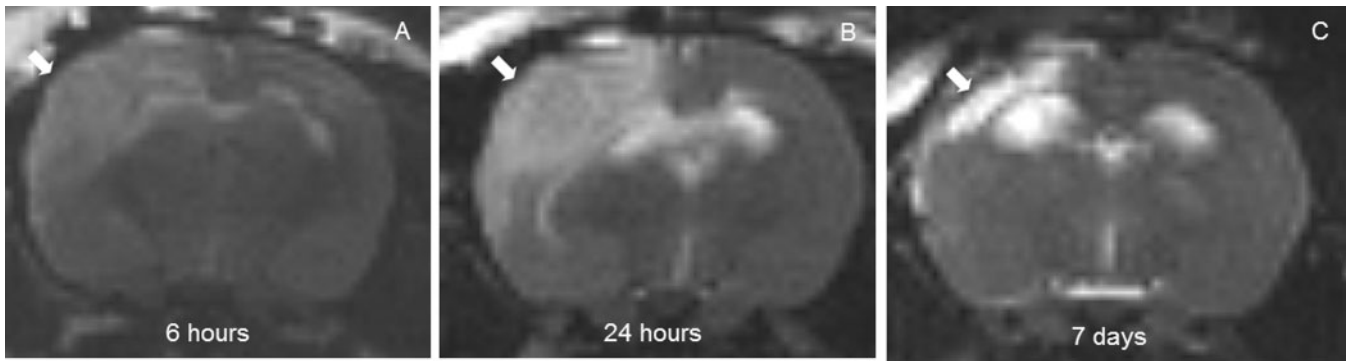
T2-weighted images depicting progressive growth of the hyperintense cortical contusion 6 (A) and 24 (B) hours, and the cystic, necrotic transformation 7 days (C, arrow bars) after CCI
